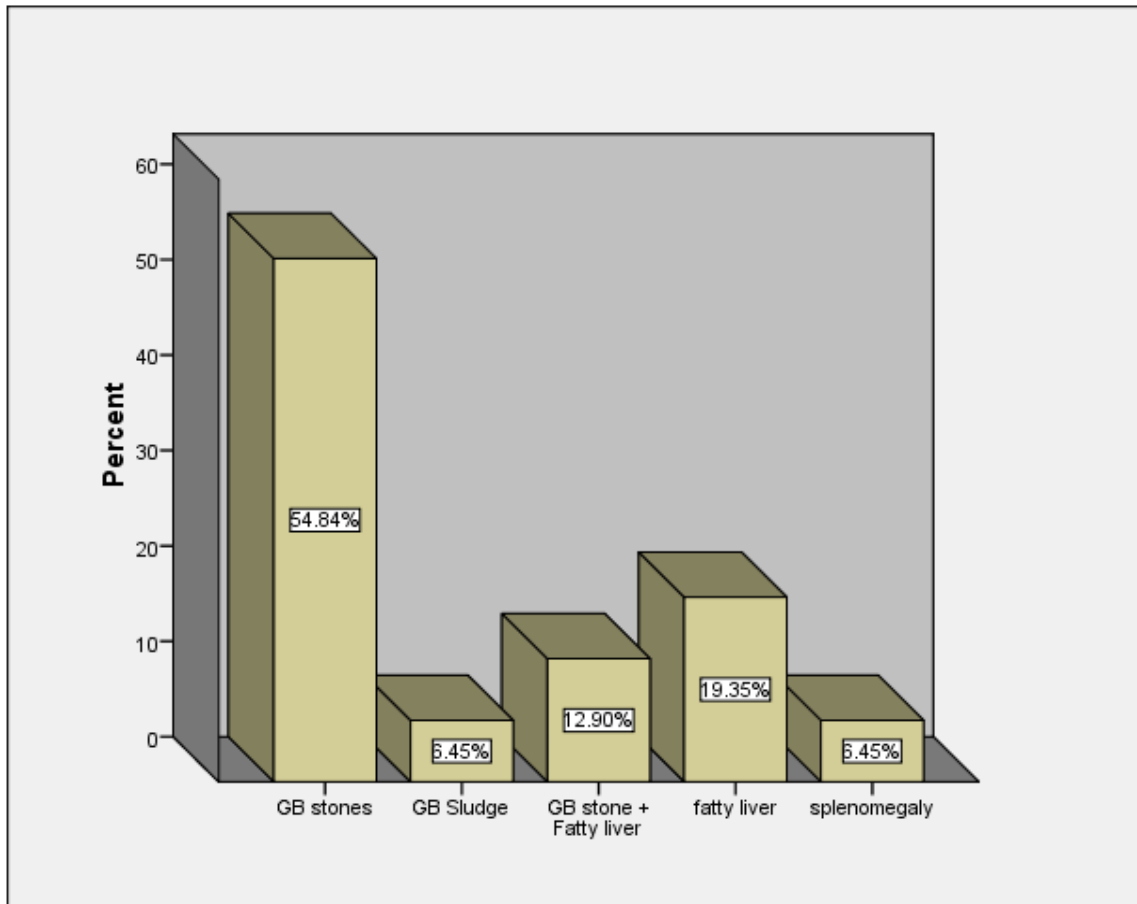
frequency distribution of ultrasound findings
